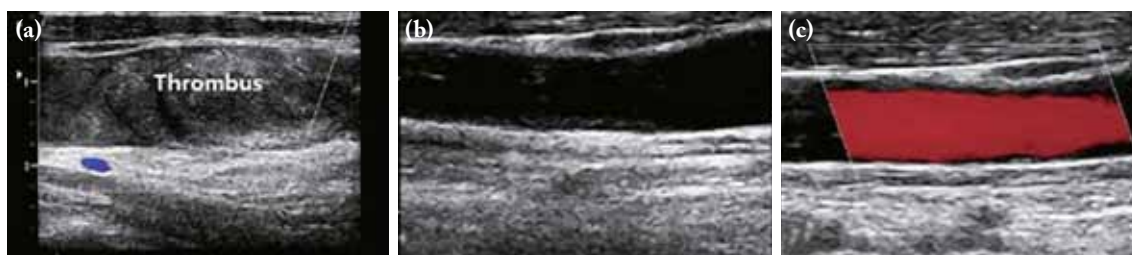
(a) The longitudinal image of the right neck shows thrombosis of the right subclavian vein with obstruction of the lumen. (b, c) The follow-up ultrasound scan reveals normalized subclavian vein.
